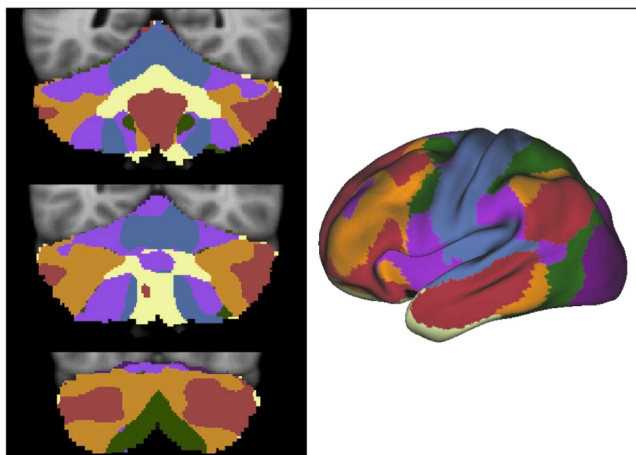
Functional relationships between cortex and cerebellum. Functional relationships between cerebellar regions (left) and canonical cortical networks (right) as assessed by functional magnetic resonance imaging ($n = 1000$). Most of the cerebellum shows functional coupling to higher order cortical regions (default mode network in red, executive control network in orange). Blue regions indicate somatomotor regions. This may be taken as evidence that the cerebellum has a role in several complex functions. Reproduced with permission from Buckner, 2011 (Buckner et al., 2011).
